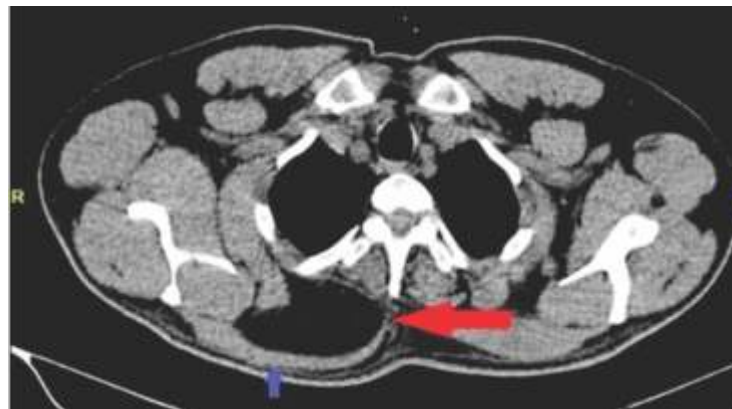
CT Scan Axial Image showing A Well Circumscribed Lobulated Low Attenuation Mass (Red Arrow) of HU-70 to -110hu below the Trapezium Muscle (Blue Arrow) on the Right Upper Back which Appears Thinned Out
